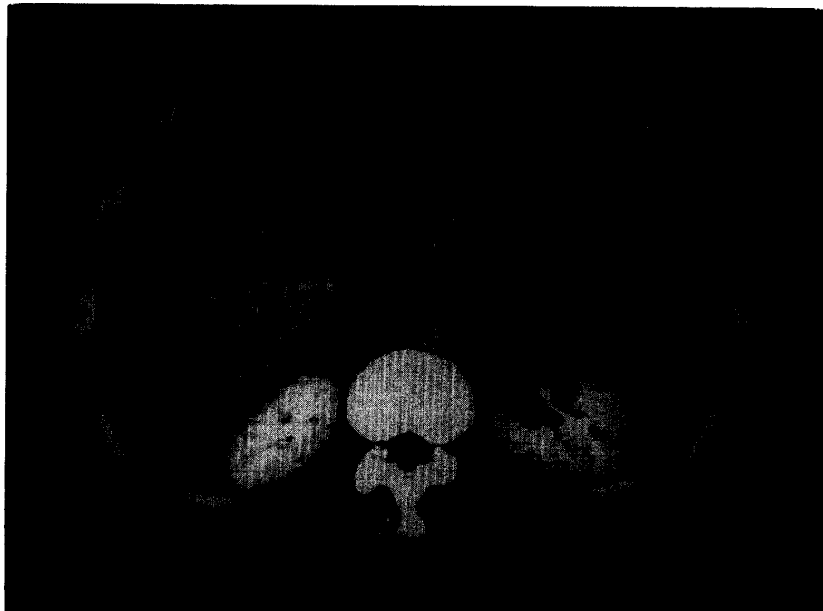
Computed tomography in case 4. Massive ascites is detectable, in which amylase level was 34360 IU/L and protein level was 3.8 g/dL.
